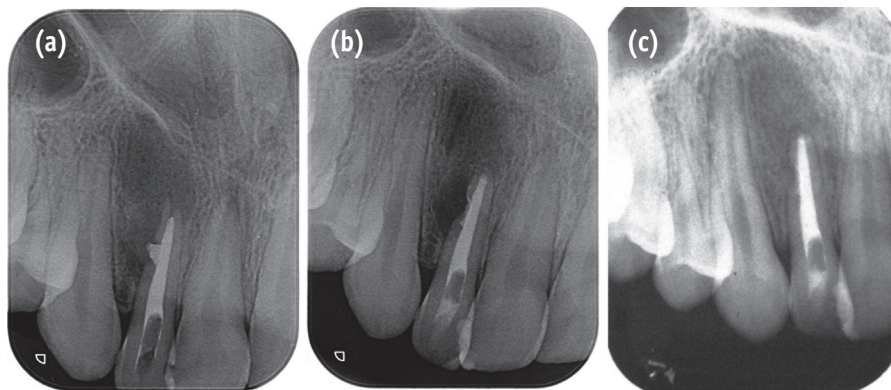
Treatment radiographs of Case 2. (a) Pre-operative radiograph; (b) Post-operative radiographs; (c) 12 month follow-up radiograph.
